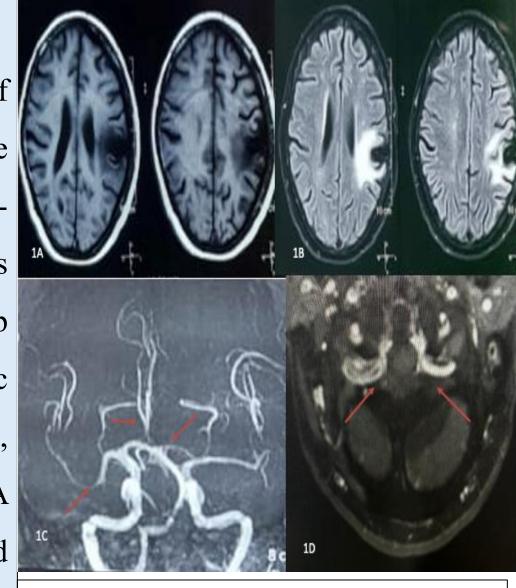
MRI Brain showing chronic infarct in left frontal region with diffuse narrowing of MCA, ACA and PCA and contrast enhancement along bilateral ICA
